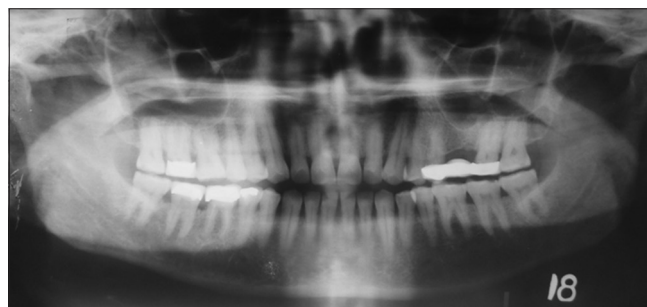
Orthopantomograph of the same patient with no pathological finding with respect to the site of lesion (left posterior maxilla)
